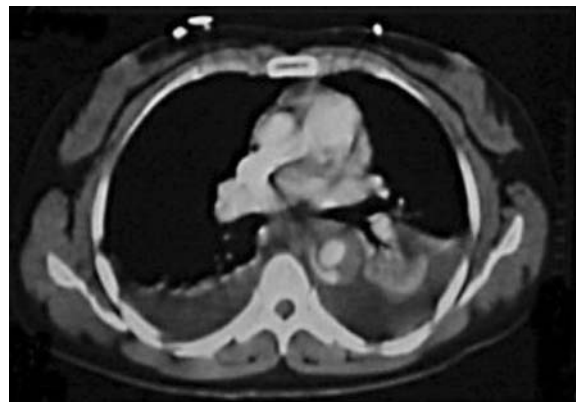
A ruptured type B dissection on computed tomography (CT) scan
